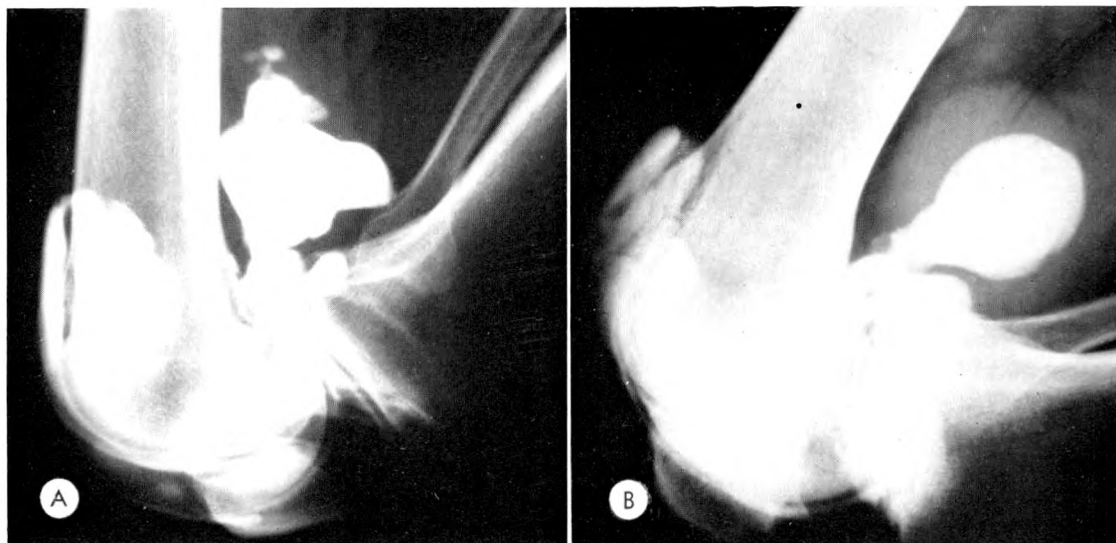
(A) Easily palpable Baker's cyst in association with a torn lateral meniscus and moderate joint effusion are demonstrated. (B) Roentgenogram shows a dry knee with "large normal" G-S bursa but no clinical findings of Baker's cyst.
